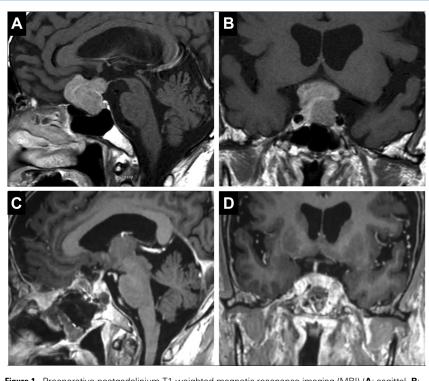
Preoperative postgadolinium T1-weighted magnetic resonance imaging (MRI) (A: sagittal, B: coronal) showing pituitary macroadenoma with superior and anterior extension. Postoperative postgadolinium T1-weighted MRI (C: sagittal, D: coronal) showing gross total removal with preservation of the pituitary stalk and gland and decompression of the optic chiasm.
